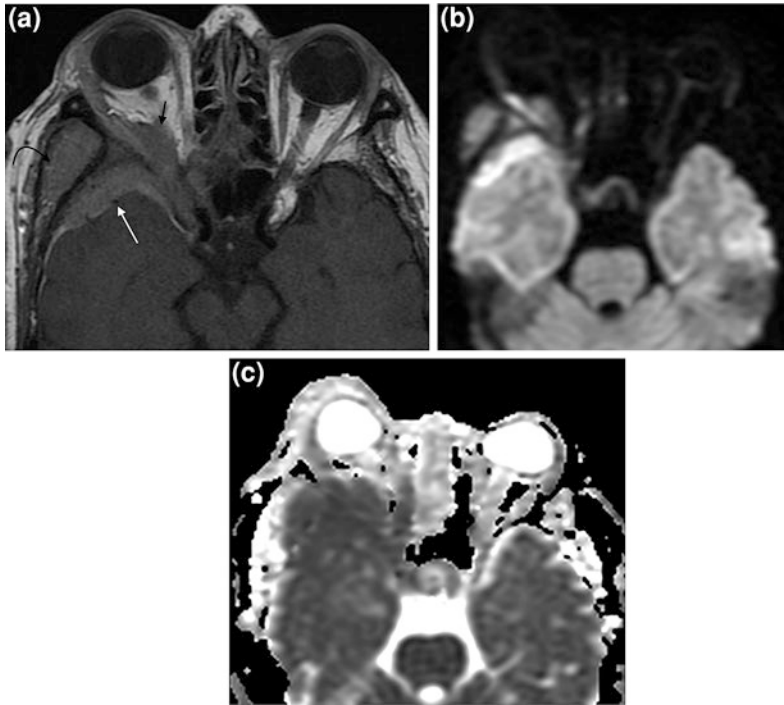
Sphenoid wing meningioma with large intra orbital, intracranial and extracranial extension. a Axial contrast-enhanced T1-weighted MR image demonstrates an enhancing lesion centered on the right greater wing of sphenoid. The lesion extends into the intra and extra-conal spaces, displacing the optic nerve and lateral rectus muscles with associated mild proptosis of the eye globe (short arrow). There is an intracranial dural based component (long arrow) as well as extracranial component (curved arrow). b and c DWI and ADC images demonstrate diffusion restriction of the lesion
